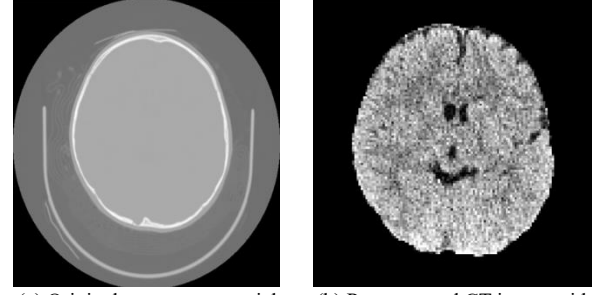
Examples of a pediatric CT before and after preprocessing (subject age: 43 months).
